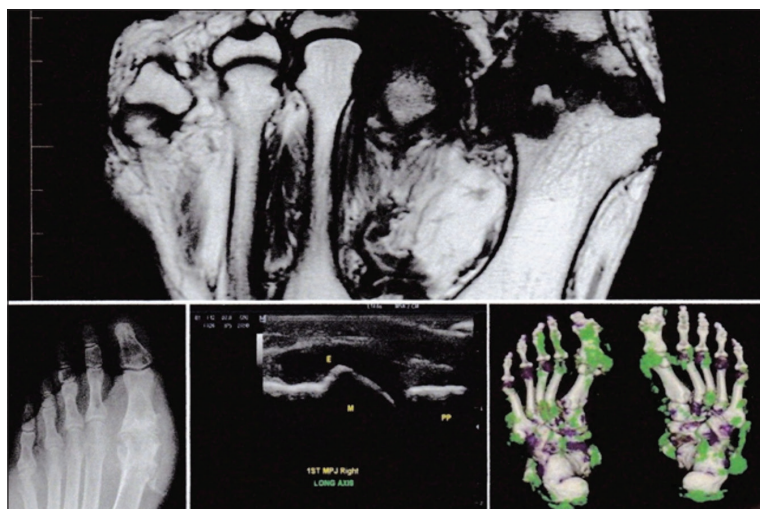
Montage showing MRI, x-ray, ultrasound, and DECT scanning.
